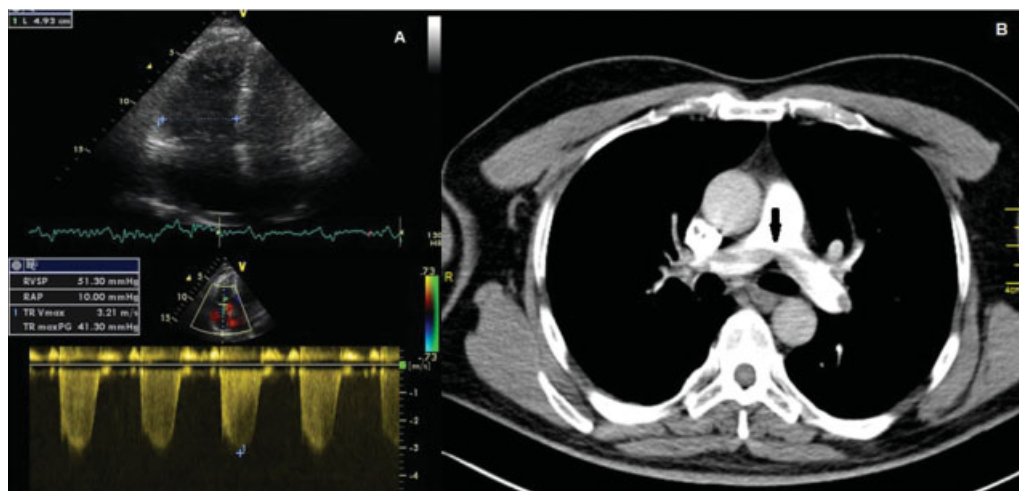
(A) Transthoracic echocardiography showed dilatation of the right cardiac chambers and increased pulmonary artery pressure (sPAB: 50 mm Hg). (B) Pulmonary computed tomography angiography showed an image compatible with thrombus in pulmonary arteries. sPAB, systolic pulmonary artery pressure.
